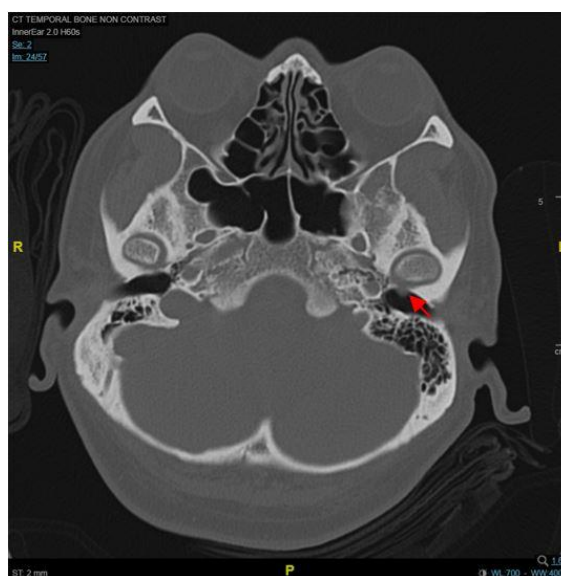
An axial CT temporal bone image at the level of the condylar head of the mandible of the temporomandibular joint. The red arrow depicts the dehiscence in the anterior bony canal wall of the left EAC, with herniation of the soft tissue of the temporomandibular joint (arrow), at the antero-inferior aspect of the medial part of the left EAC measuring 0.4 x 0.2 cm (AP x W).
